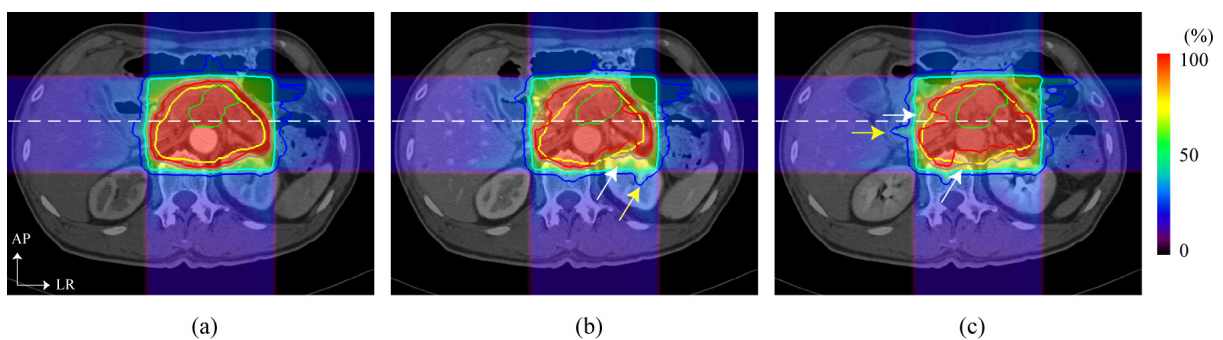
Carbon ion beam dose distribution in axial and coronal sections using contrast enhanced multi-phase CT images at time (a) 0 s (reference CT), (b) 35 s, and (c) 145 s. Green and yellow lines show gross tumor volume and clinical target volume contours, respectively.
